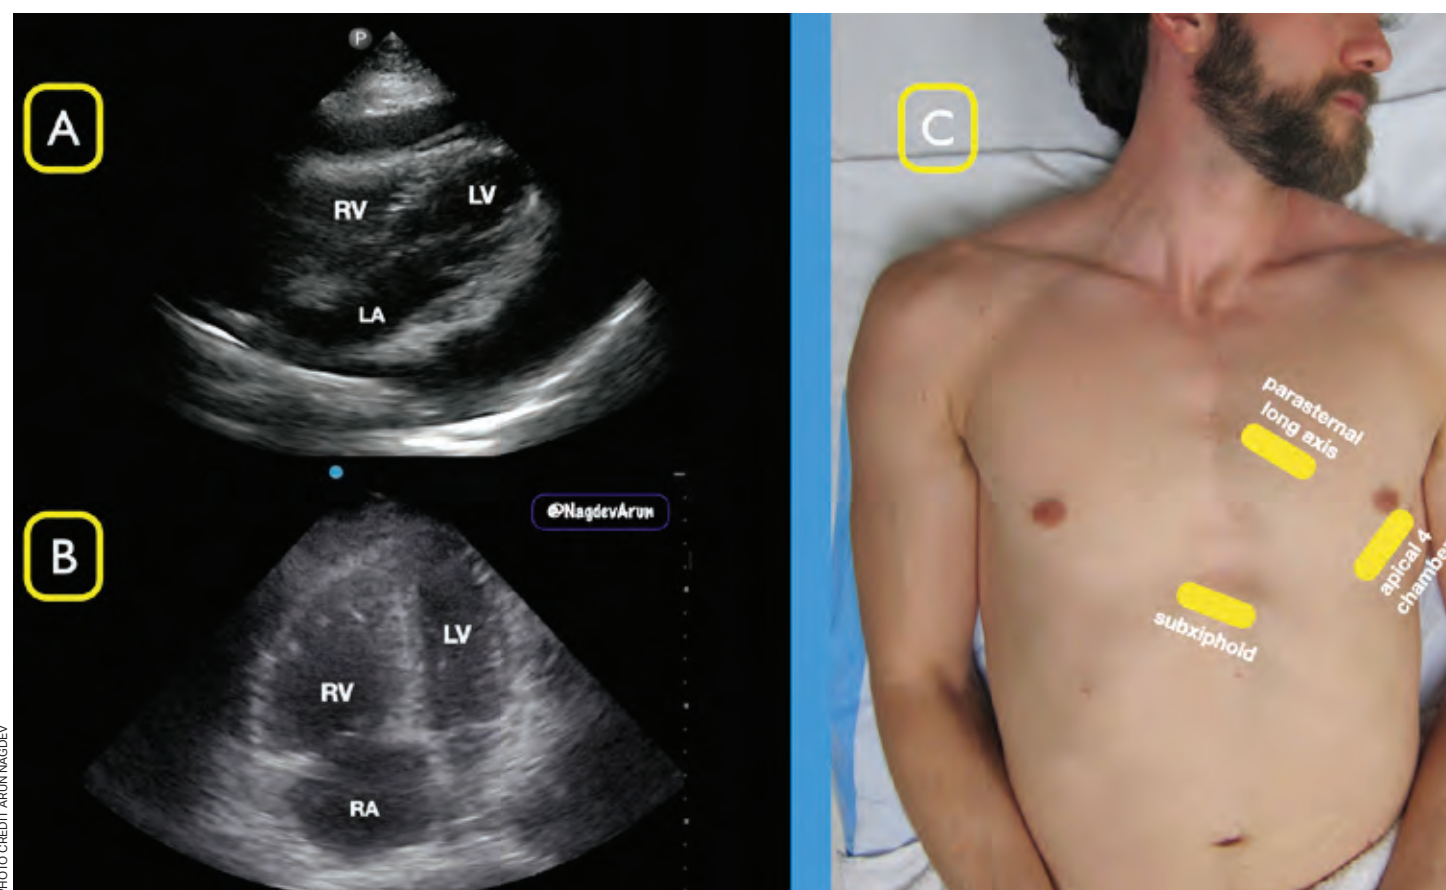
A) Subxiphoid view demonstrating a pericardial effusion with signs of echocardiographic tamponade B) Apical four-chamber (A4C) view demonstrating right ventricular strain in a patient with a massive pulmonary embolism C) Three views of the heart when attempting to find a good window to image during cardiac compressions
